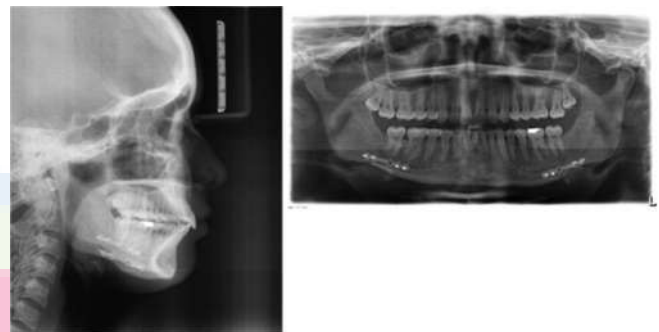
Posttreatment radiographs of case report 1
